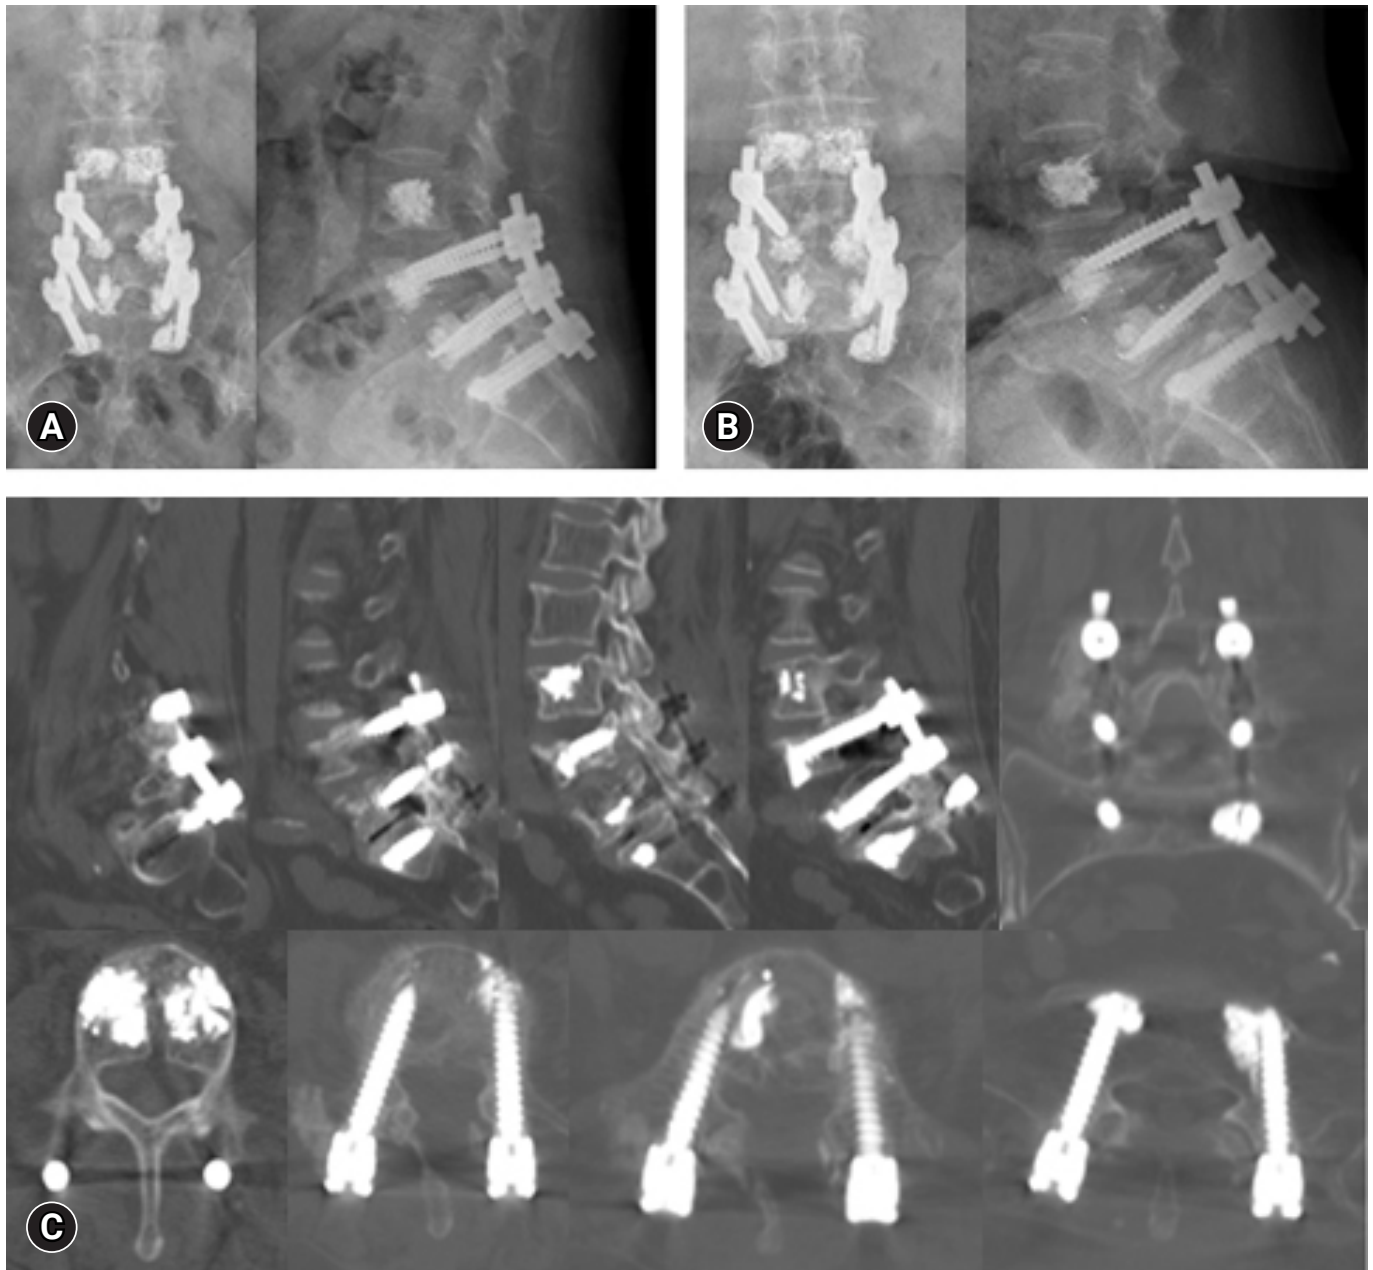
Follow-up images. (A) X-rays after 1 month. (B) X-rays after 6 months. (C) Computed tomography after 3 months.
